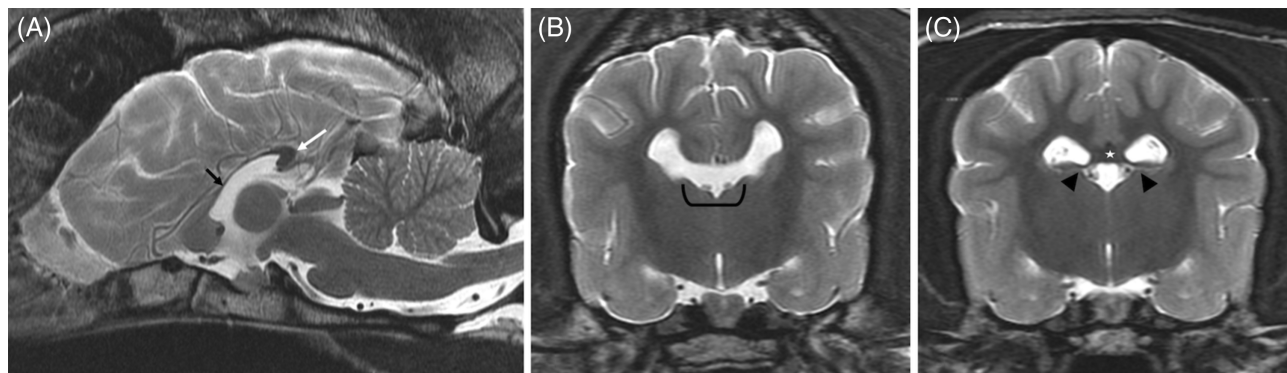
A, Midline sagittal T2-weighted image of the corpus callosus malformation (CCM) subject demonstrating the splenium (white arrow) which is the only visible portion of the corpus callosum and hypoplastic fornix (black arrow). B, Transverse mid-brain T2-weighted image of the CCM subject demonstrating the lack of the dorsal wall of the 3rd ventricle and connection between the 3rd and lateral ventricles (black bracket). C, Transverse mid-brain T2-weighted image of the control subject demonstrating the visible corpus callosum (white star) and separation of the ventricular structures (black arrow heads)
